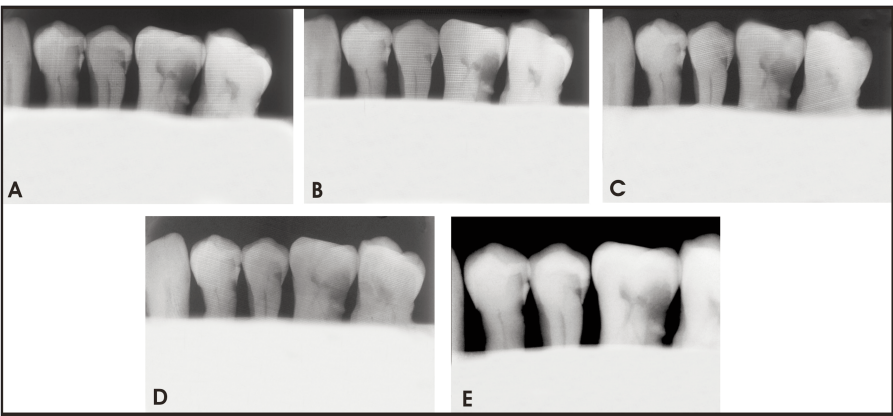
Examples of images evaluated in the study. A: An example of Ektaspeed Plus; B: An example of Agfa Dentus M2 Comfort; C: An example of Insight; D: An example of Flow X-ray FV 58; E: An example of RVG.
